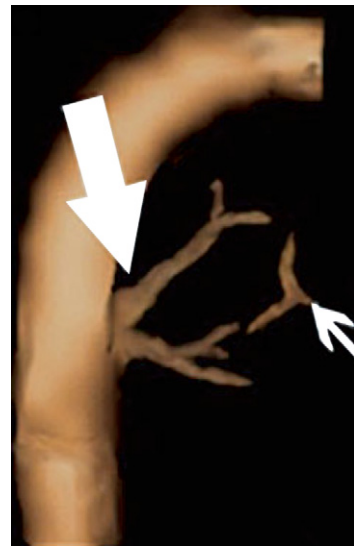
B-flow 3D rendering from a spatial-temporal correlation volume of a major aortopulmonary collateral artery (*small arrow*) (large arrow: pulmonary arteries). (From Volpe P, Campobasso G, Stanziano A, et al. Novel application of 4D sonography with B-flow imaging and spatio-temporal image correlation (STIC) in the assessment of the anatomy of pulmonary arteries in fetuses with pulmonary atresia and ventricular septal defect. *Ultrasound Obstet Gynecol* 2006;28:40–6; with permission.)
